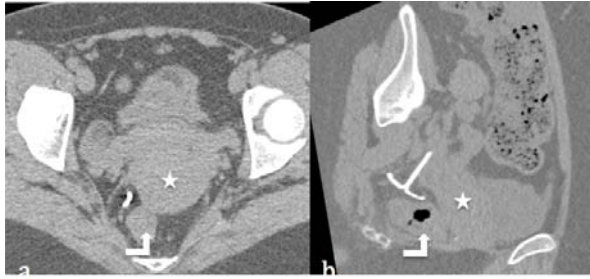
Non-enhanced CT scan of the pelvis in axial (a) and reformatted sagittal oblique (b). The T shape IUD is completely extra-uterine located anterolateral to the rectum (bent arrow) and postero-lateral to the uterus (star). The uterine outline is normal.
